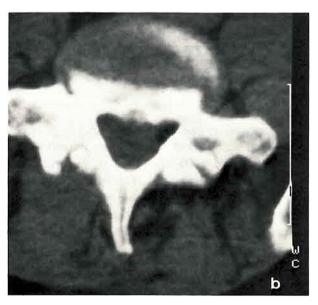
b. Additionally to Fig. 1 a a paravertebral mass of homogeneous density is visible involving the paravertebral muscles at the level of the disc of  $1.4/_5$ . Fat is entirely absent on the alfected side. The abscess cavity as it is seen in the MR section cannot be identified in the CT scan
